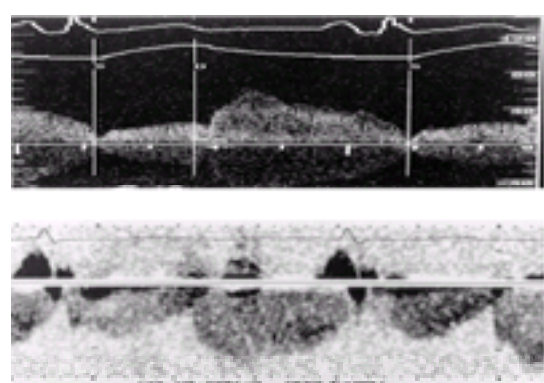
Comparison of coronary spectral flow velocity by two Doppler techniques. Top: Flow velocity spectra in a normal coronary artery using the intracoronary Doppler guidewire. Bottom: Flow velocity in the left anterior descending artery obtained with transesophageal echocardiography. Note the similarities of phasic pattern, although the direction of flow is inverted for the transesophageal Doppler signal. Scale for top panel: 0 to 160 cm/sec. Scale for bottom panel: 20 cm/division. Peak flow velocity for both signals is approximately 50 cm/sec.
